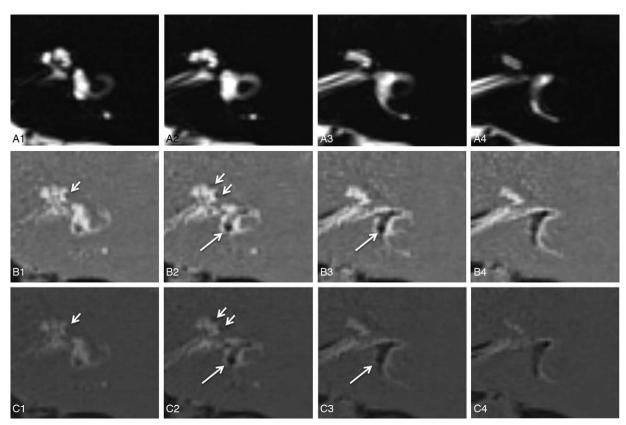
Representative images of the normal endolymphatic space in the ampulla of the posterior semicircular canal (SCC). *A*, T2-weighted magnetic resonance cisternography is used to evaluate the anatomy of all fluid-filled labyrinth spaces. This image shows the regular anatomy of the vestibule and lateral SCC. *B*, T2-weighted three-dimensional Fluid Attenuated Inversion Recovery (3D-FLAIR) is used to visualize endolymphatic hydrops (EH). *C*, Hybrid of reversed image of positive endolymph signal and native image of positive perilymph signal (HYDROPS) is used to identify EH more clearly than T2-weighted 3D-FLAIR. The normal endolymphatic space in the ampulla is observed in the posterior SCC (black area in B2, C2, B3, and C3, the long *arrow*), and no vestibular EH is detected in (*B*) and (*C*). The short *arrows* show significant cochlear EH in B1, B2, C1, and C2.
